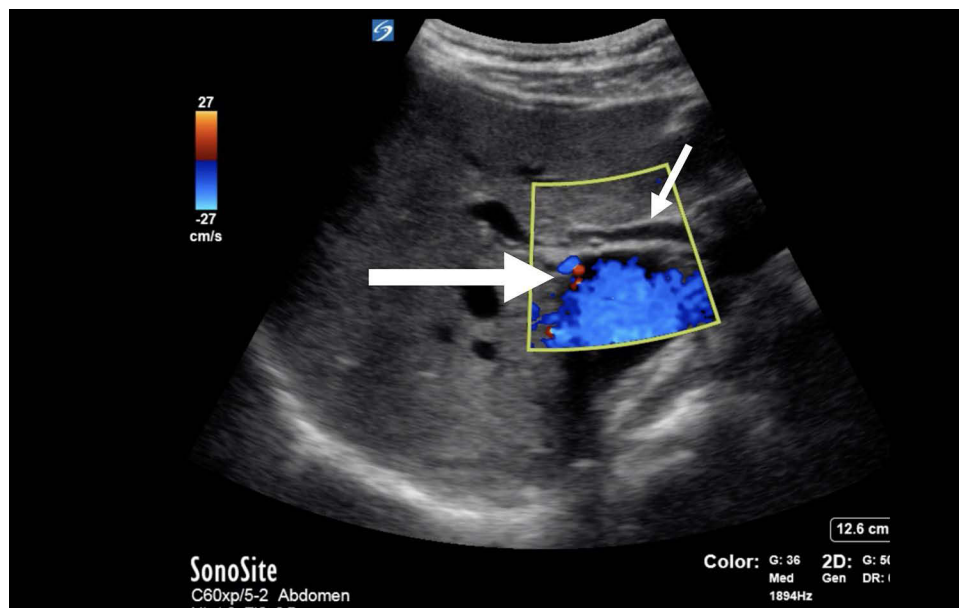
Normal sonographic appearance of the common bile duct. Large arrow represents portal vein with color Doppler applied. Small arrow represents common bile duct.
